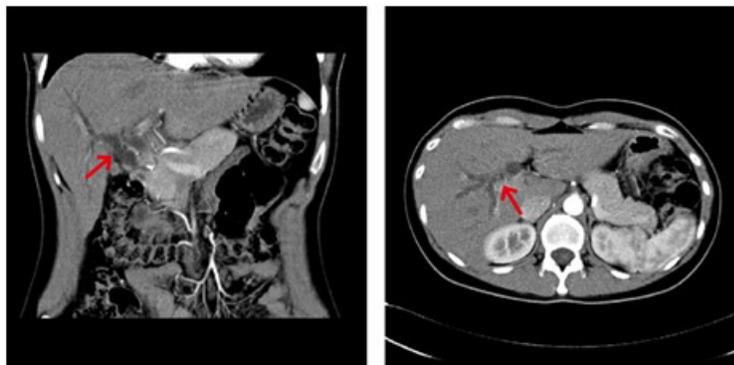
Computed tomography (CT) demonstrating biliary obstruction. The wall of the upper segment of the common bile duct was thickened and narrowed, and the intrahepatic bile duct was dilated (red arrows).
